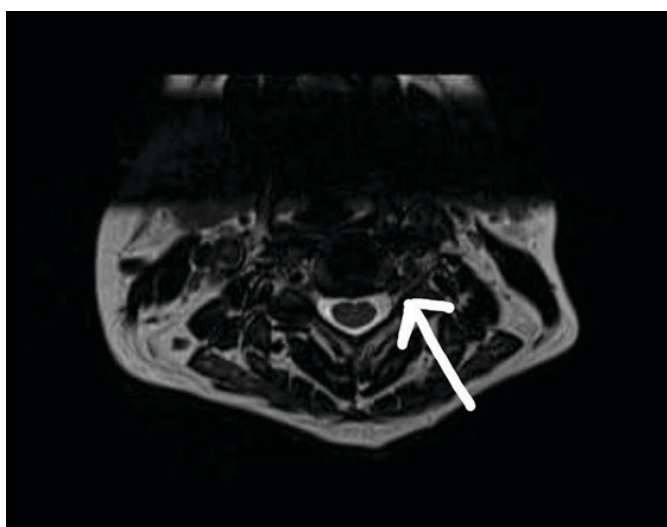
Single T2W axial MRI image of cervical spine showing left paracentral disc herniation with narrowing of exit foramen.
